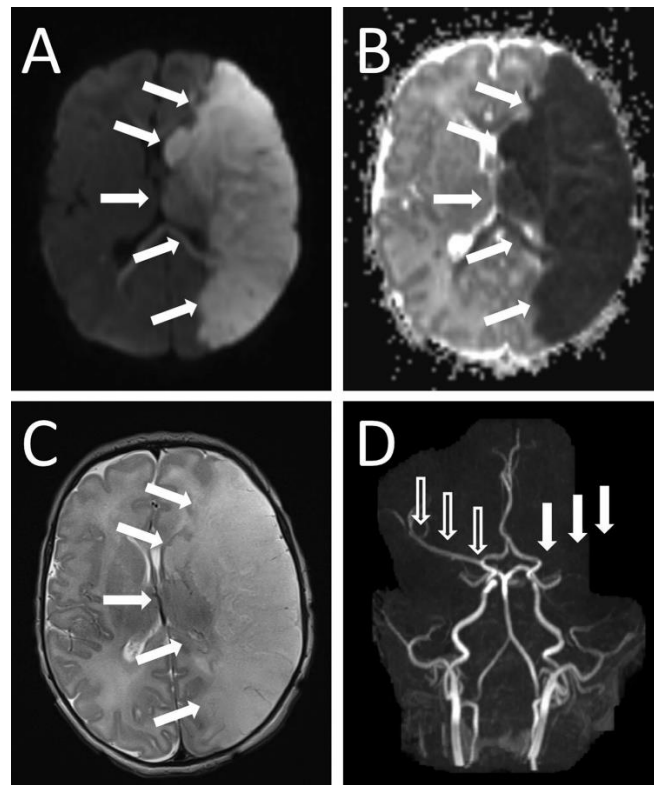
MRI and MRA images of the brain of a term neonate with NAIS. Images show a large infarct in the area of the MCA. This image was published by Bernson-Leung et al. (191) with the following legend: Term neonate presented with right eye twitching at delivery. Axial images showed restricted diffusion indicating acute ischemia (bright on trace image [A] and dark on ADC map [B]) occupying the entire left MCA territory (arrows). C. Sulcal effacement and obliteration of the gray-matter/white-matter junction are seen on the axial T2 sequence. D. Magnetic resonance angiography showed absent flow signal in the expected location of the MCA due to occlusion (solid arrows indicate expected course as compared to white outlined arrows that indicate course of right MCA). He developed infantile spasms at 5 months. At 13 months, he had a spastic hemiparesis, could sit but not crawl, and had no specific words. MCA = middle cerebral artery.
